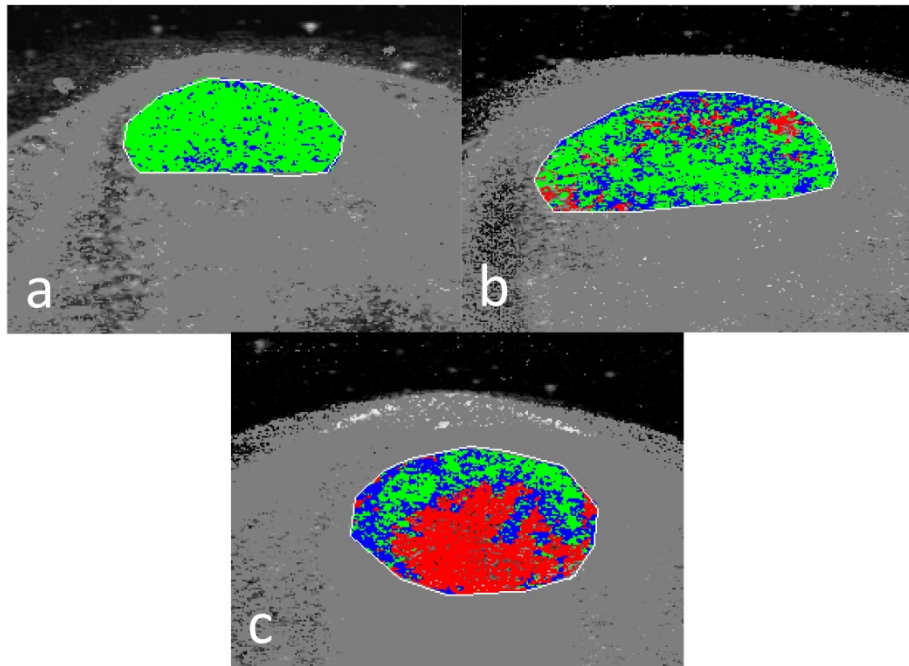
Ultrasound tissue characterisation (UTC) of the Achilles tendon midsubstance. (a) Normal Achilles tendon characterised by a high proportion of echo-type I (green pixels) representing aligned tendon bundles. (b) Reactive tendinopathy due to tendon thickening and the presence of diffuse speckling of echo-type II (blue pixels) and echo-type III (red pixels). (c) Degenerative tendinopathy indicated by significant focal area of echo-type III (red pixels).
